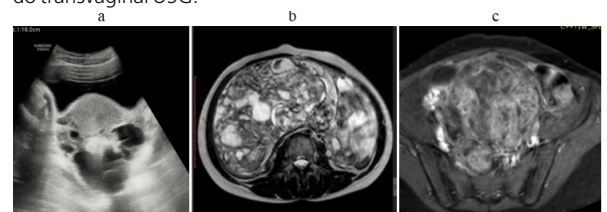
Immature teratoma of right ovary. a:USG showing a large heterogeneous pelviabdominal solid cystic lesion. Bilateral ovaries were not separately visualized. b: MRI shows large well defined lobulated solid-cystic lesion extending from L1 to S4 vertebral body level hyperintense on T2W and fat suppressed sequences, showing multiple areas of fat and cystic areas within. c: Heterogeneous post contrast enhancement.
